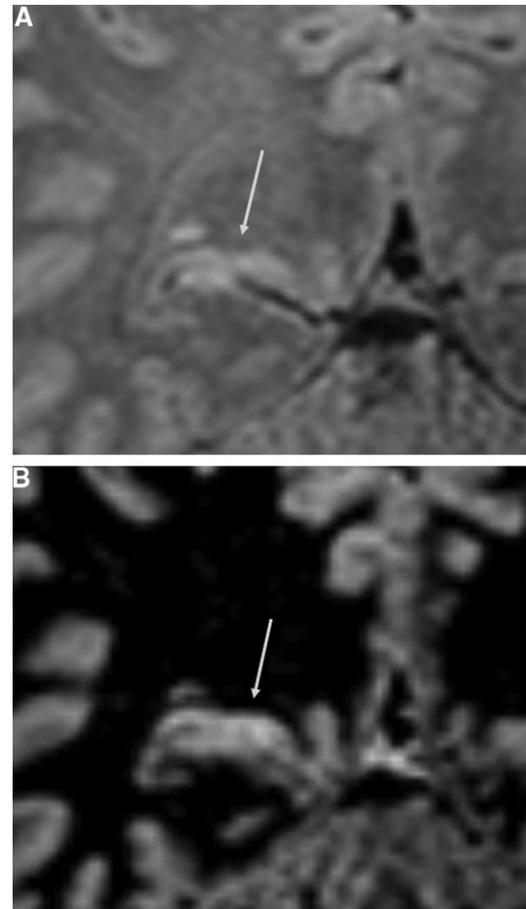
A 40-year-old woman with FCD. (A) Coronal 3D FLAIR and (B) 3D DIR images show the presence of FCD. Thickening of the cortex with mild hyperintensity is visible in the right parietal lobe (arrows A and B). The FCD lesion is more conspicuous on the 3D DIR image (arrow B).
